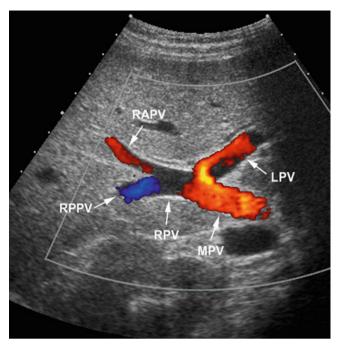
Main portal vein and its branches. Color Doppler sonogram of the porta hepatis showing the main portal vein (*arrow*, *MPV*), branching into the left portal vein (*arrow*, *LPV*) and right portal vein (*arrow*, *RPV*), as well as bifurcation of the right portal vein into anterior (*arrow*, *RAPV*) and posterior (*arrow*, *RPPV*) branches
